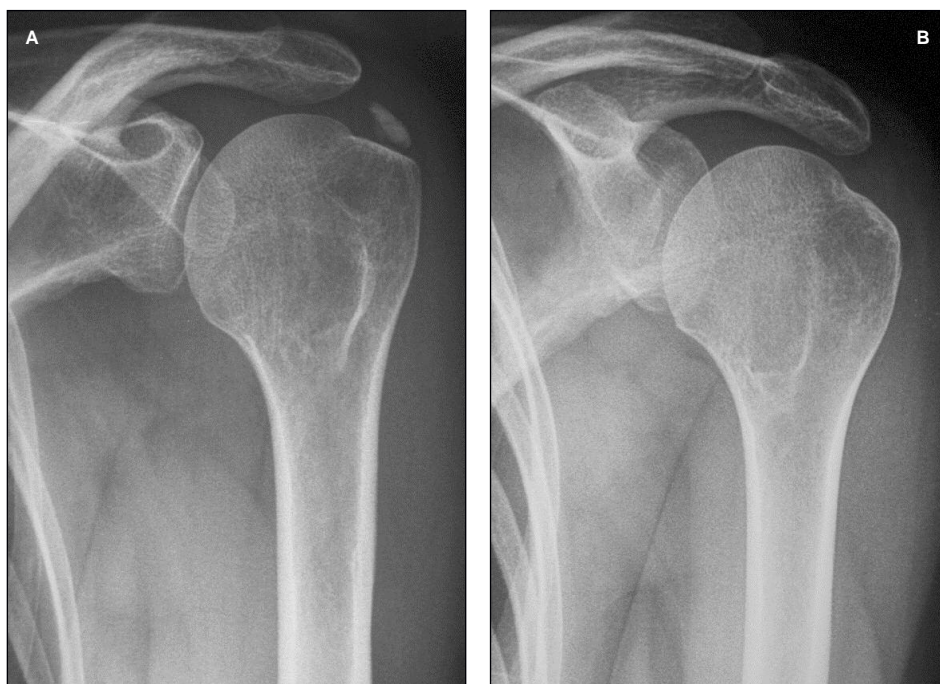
Radiographic examination of a left shoulder with Type A calcification before surgery (A) and at follow-up (B).
